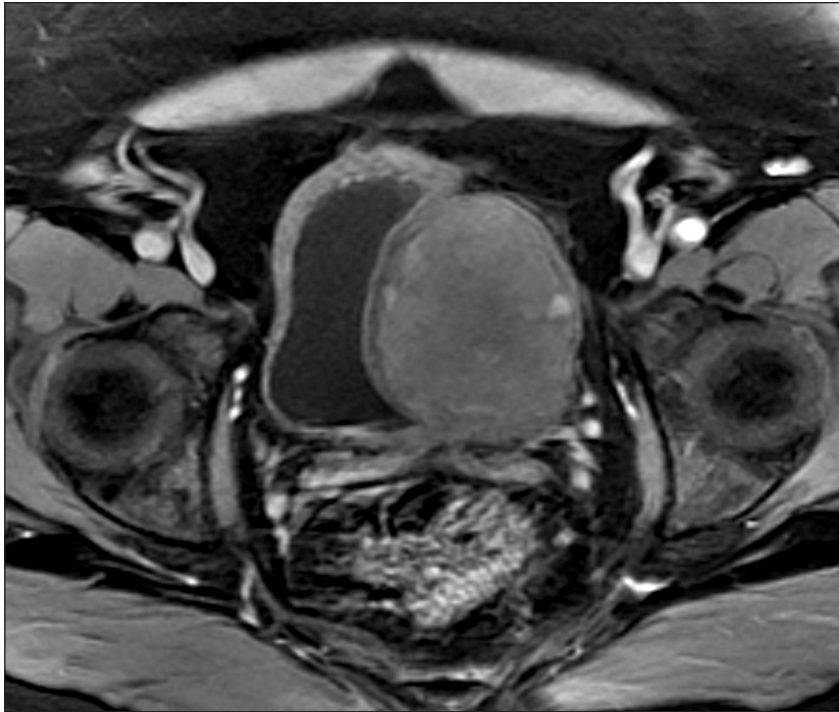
Magnetic resonance imaging shows a solid mass measuring 7.5 x 4.9 x 6.8 cm on the wall of the urinary bladder
